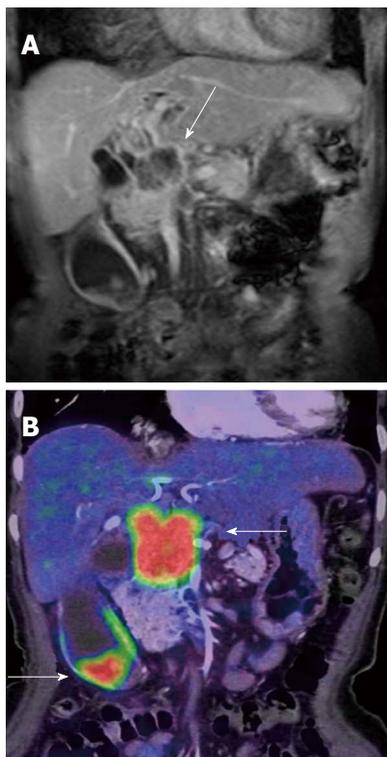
Gall bladder cancer with lymph node metastases near the pancreatic head. A: CE-MRI (coronal section) shows poorly enhanced tumor near the pancreatic head (arrow). The tumor was thought to be a primary lesion at first; B: PET/CT (with CE) demonstrated two FDG-avid lesions (arrow). Gall bladder cancer and its metastases usually show strong FDG deposits.
